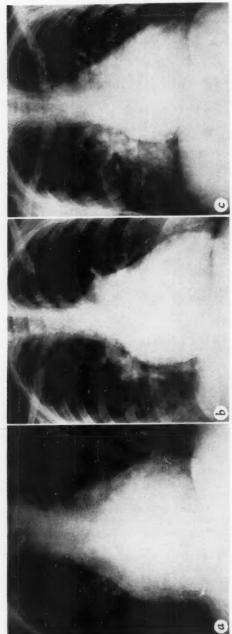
a to f. Posteroanterior roentgenograms of the thorax in cases 1 to 6, respectively. Diffuse enlargement of the cardiac silhouette is uniformly present in all cases, as described in the text.
